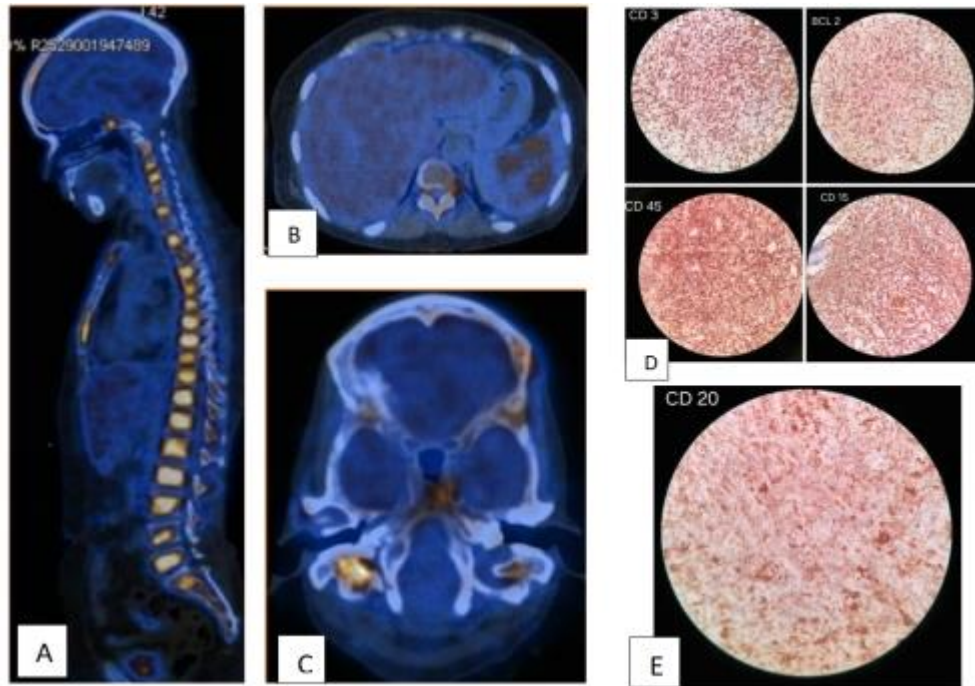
(A) Increased FDG uptake in pre and paravertebral regions of lower dorsal and upper lumbar vertebrae.
